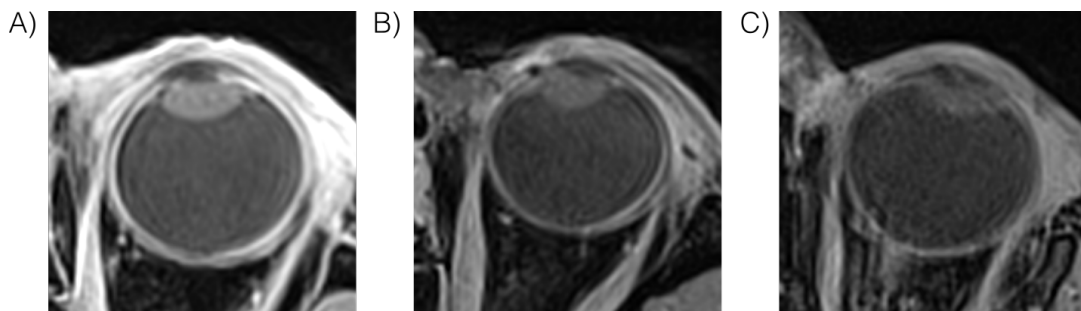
Limiting factors of MRI : A-C) Three MRI scans from different adult patients. The region of the eyes is blurred due to the eye movement and saccades. Patients often need to remain immobile during 3-5 minutes.
